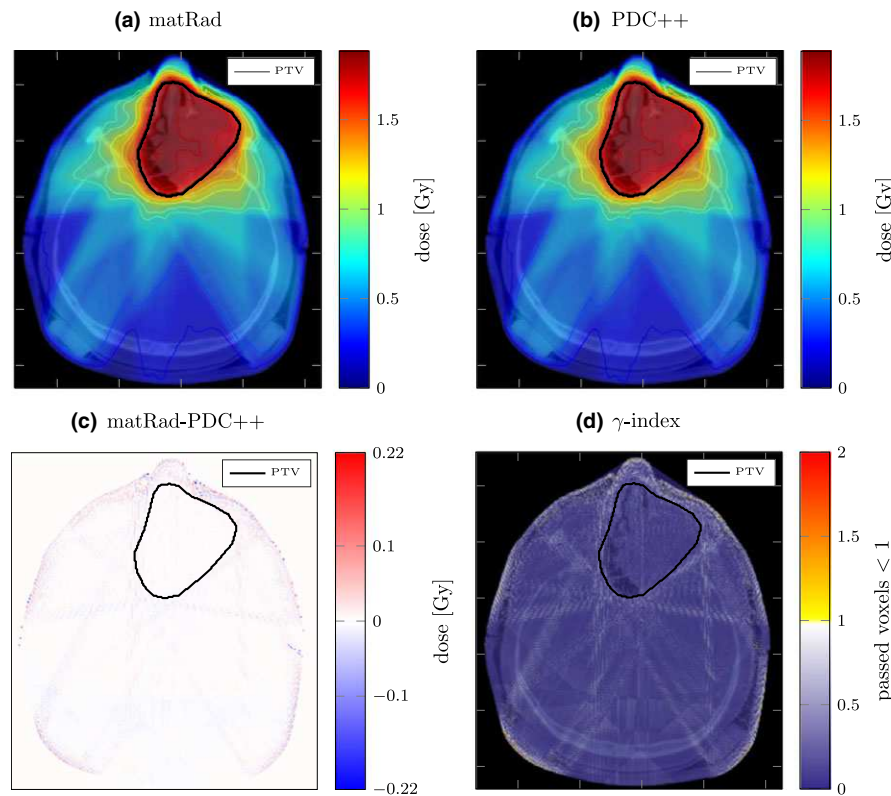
Transversal slices of an intensity-modulated photon therapy treatment plan using seven beams with gantry angles of  $0^\circ$ ,  $52^\circ$ ,  $103^\circ$ ,  $154^\circ$ ,  $206^\circ$ ,  $257^\circ$ , and  $309^\circ$  — corresponding couch angles are  $0^\circ$ . The CT data overlaid with a transparent dose colorwash and isodose lines are shown in (a) and (b). (a) Dose distribution computed with matRad. (b) Dose distribution computed with PDC++. Their absolute difference is shown in (c) and the result of the  $\gamma$ -analysis ( $dta = 2$  mm,  $\Delta d 2\%$ ) is superimposed on the CT in (d). The global pass rate ( $\gamma \leq 1$ ) amounts to 99.82%.
